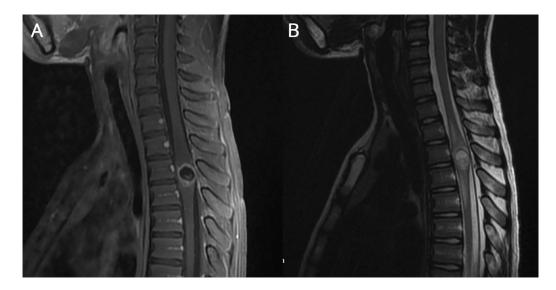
MRI Spine images demonstrating spinal Neurocysticercosis⁹⁹
